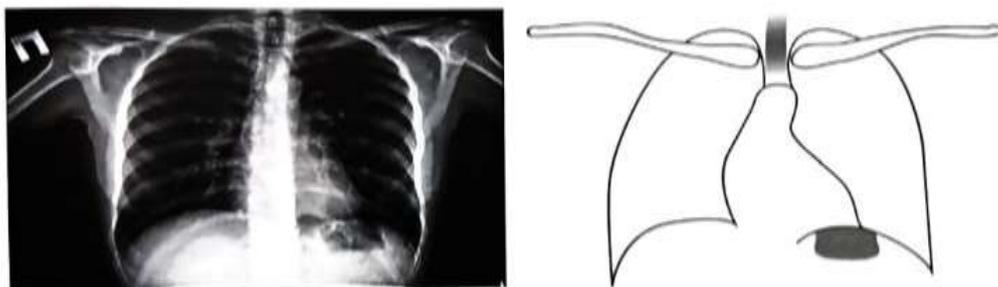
Normal chest radiograph
